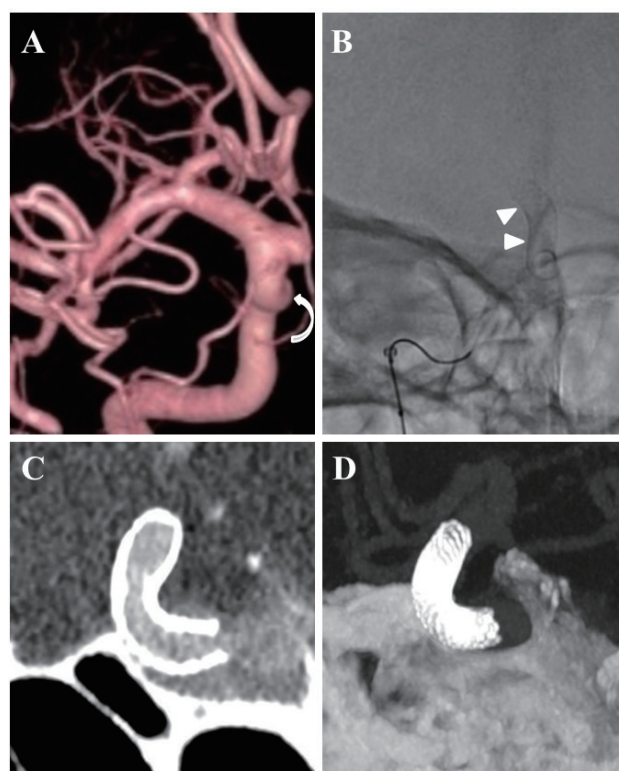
Imaging findings in a 50-year-old woman. Pretreatment three-dimensional (3D) computed tomography angiography (A) reveals aneurysm of the right internal carotid artery - superior hypophyseal artery (curved arrow). Digital subtraction angiography at anterior-posterior view (B) demonstrates position of the implanted flow-diverting stent (arrowheads). Sagittal (C) and 3D maximum intensity projection (D) images of the follow-up photon-counting detector CT in a single-acquisition high-resolution mode with the iterative metal artifact reduction and utilization of the convolution kernel Hr 56 for attainment of reconstructed images with the slice thickness of 0.2 mm clearly demonstrate positioning and structure of the stent within the lumen of the artery.
